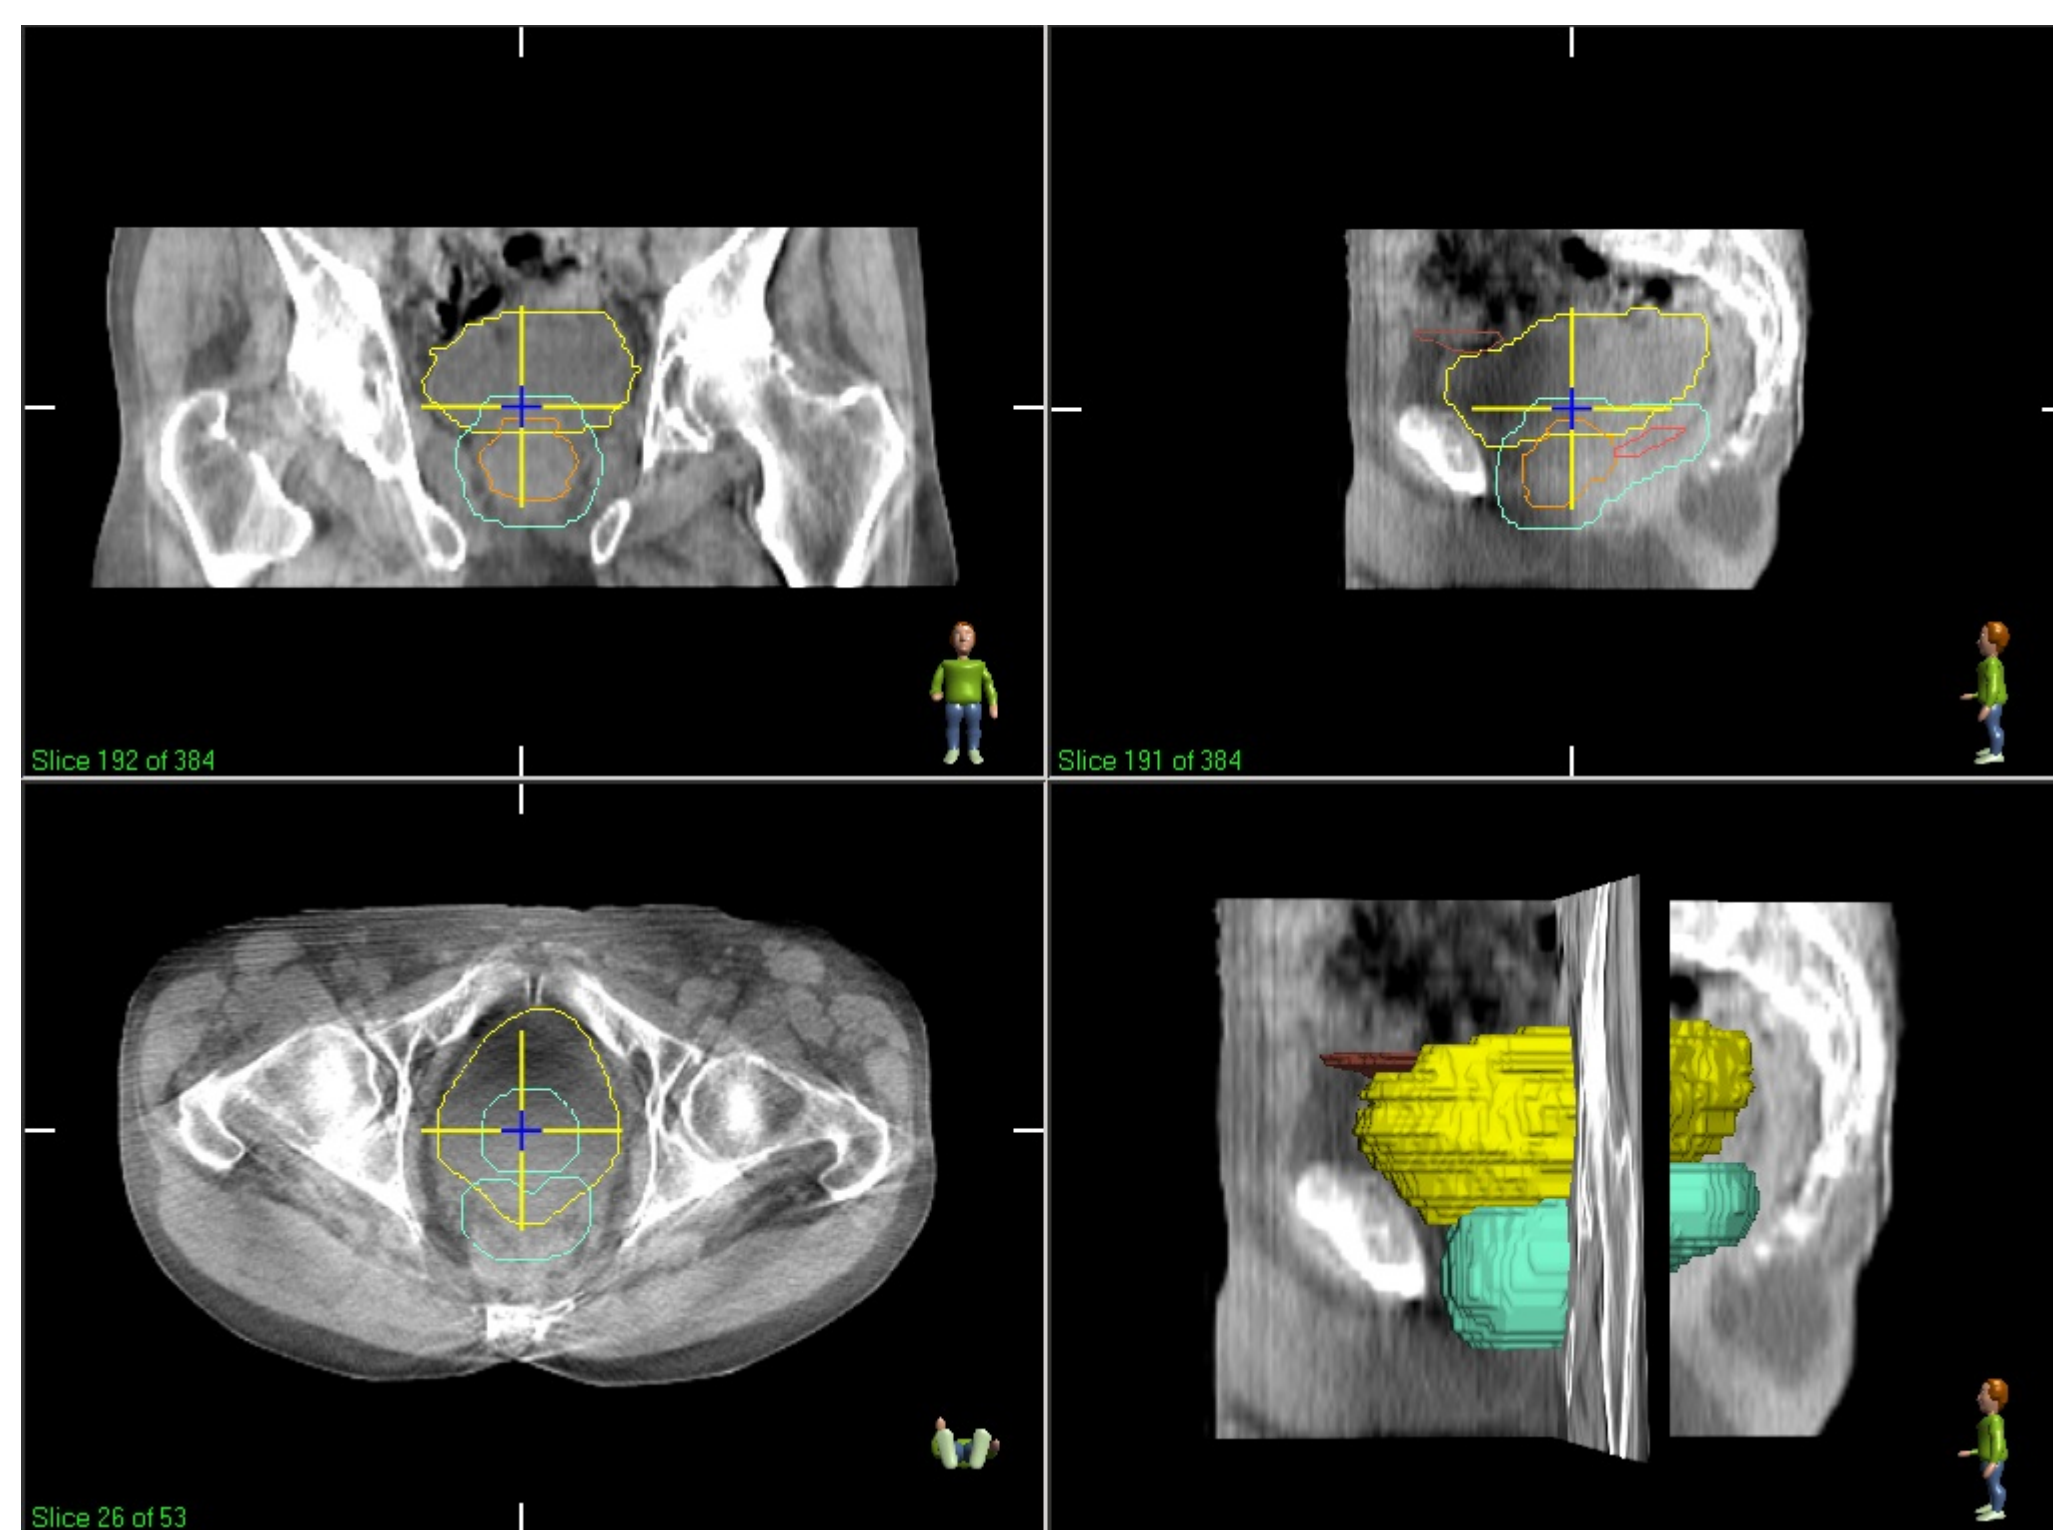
A Cone-Beam CT scan with contoured regions of interest: bladder (yellow); prostate (orange); seminal vesicles (red); and treatment planning volume (aqua).
